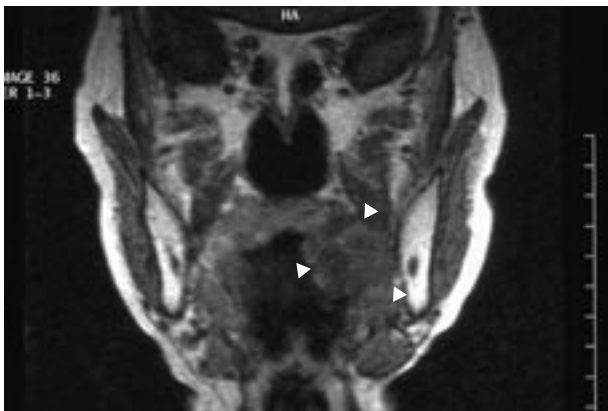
T1-weighted magnetic resonance image (MRI) shows an unclear low signal in the left retromolar region.
